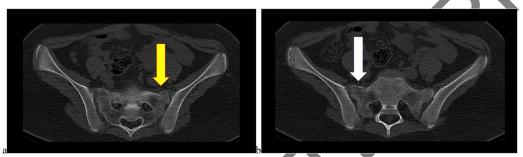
3b: Axial sections of pelvic computed tomography showing the maximum displacement at the left (yellow arrow) and right (white arrow) sacroiliac joints. This image was obtained at the reforral hospital where the authors are currently working.
